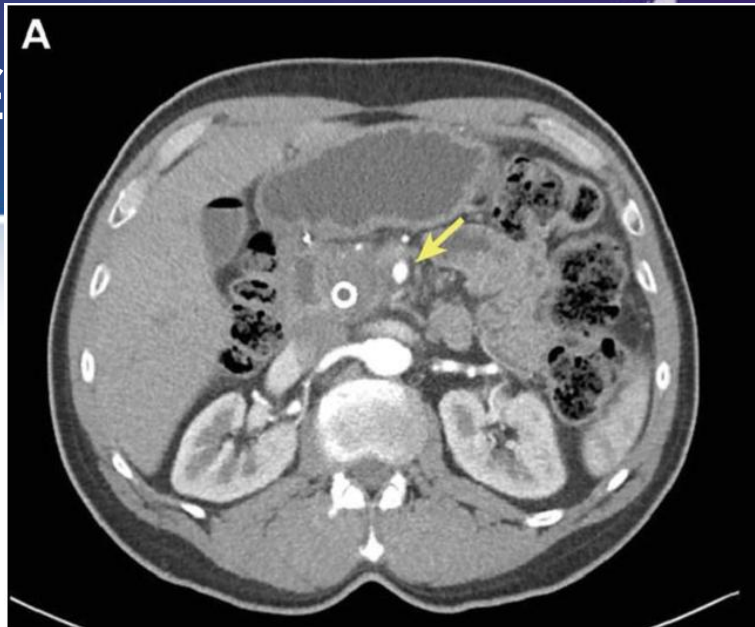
CT of Pancreatic Cancer. A resectable pancreatic cancer with a well-defined fat plane around the superior mesenteric artery (arrow).
